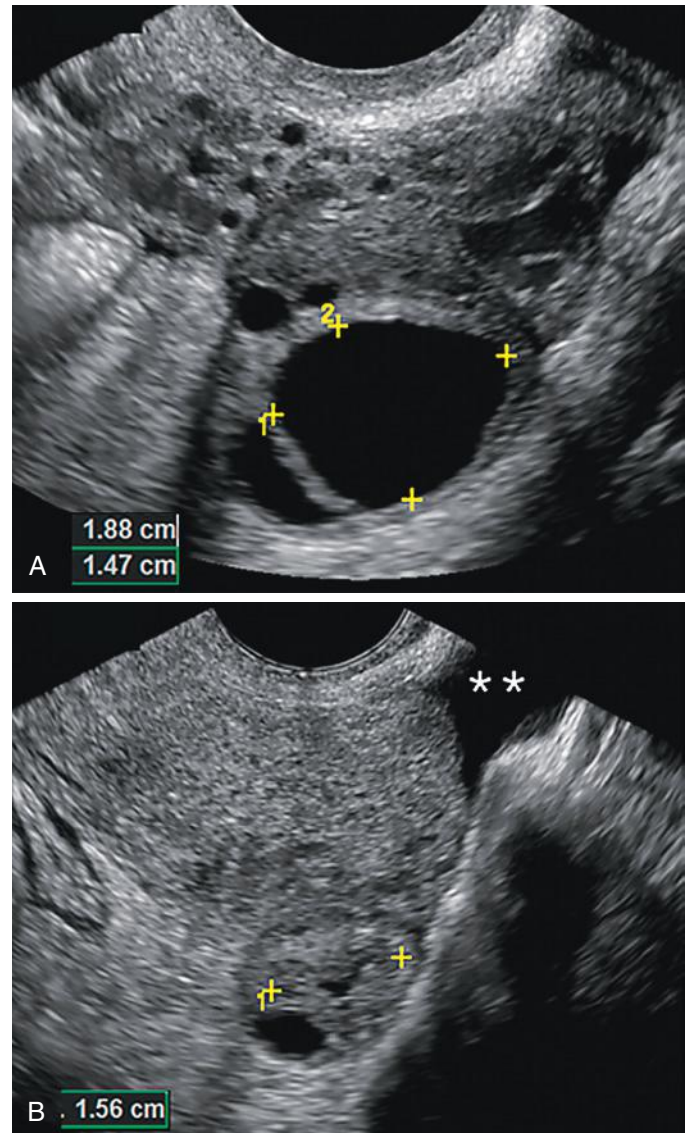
Role of ultrasound in monitoring ovarian development. A, Coronal gray-scale image of the left ovary shows two anechoic cysts or follicles. The larger follicle measures approximately 19 × 15 mm (*calipers*). B, Transvaginal sonographic image of the same ovary, 2 days later. The 19-mm anechoic follicle is no longer seen. There is a small complex cyst (*calipers*) in the same location within the left ovary and new trace volume of free fluid (*asterisks*). These findings suggest interval ovulation with creation of corpus luteum (*calipers*), measuring 1.56 cm in diameter.
